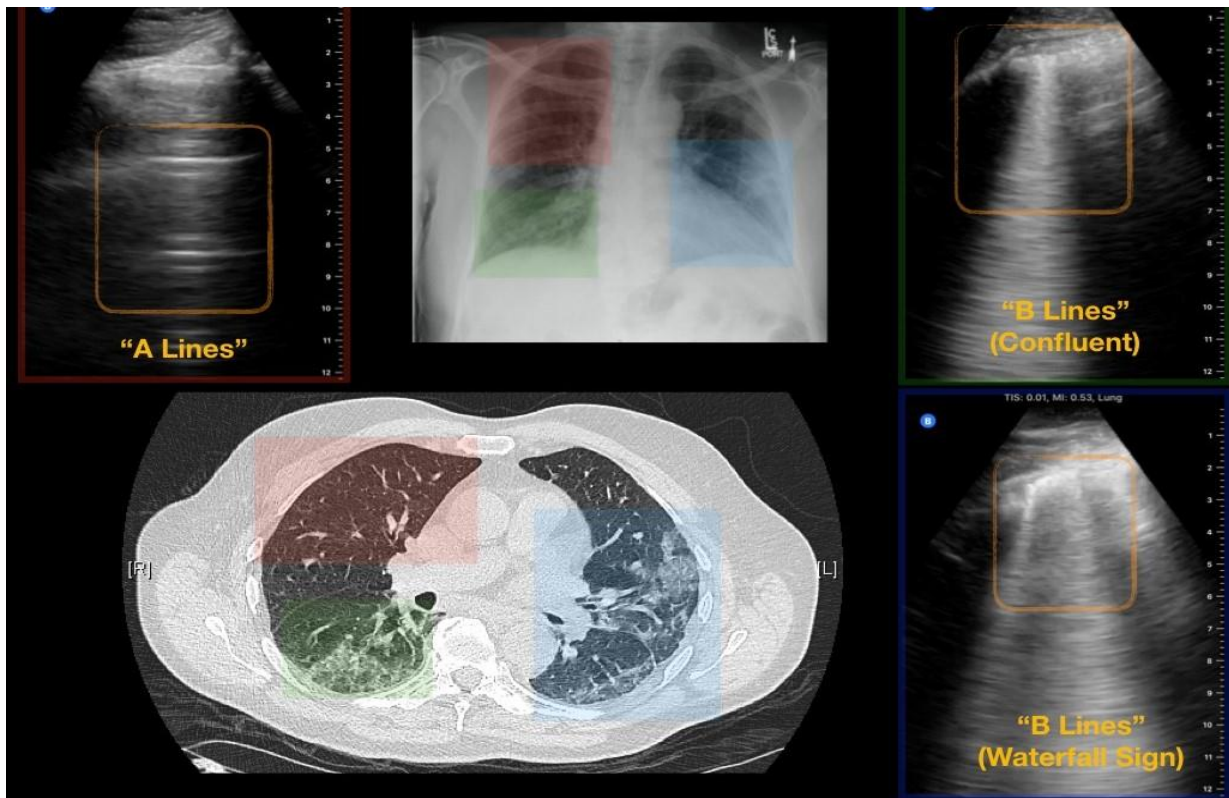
56year old COVID-19 female patient. Day 10 since symptom onset. Lung ultrasound shows discrete and confluent “B-Lines”, Consolidation and Pleural thickening. CXR shows bilateral opacification and CT scan shows ground-glass opacities.
